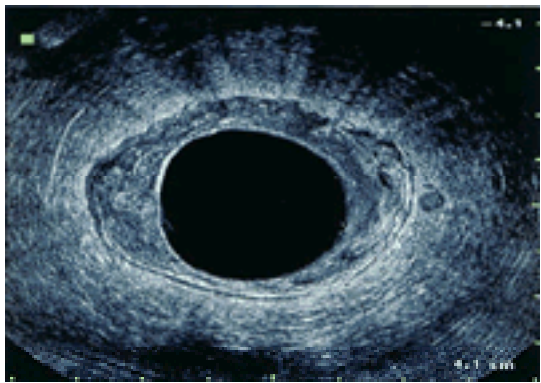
A transmural (T3N1) rectal cancer on endorectal ultrasound (it is important to remember that there is no serosa in the lower two-thirds of the rectum).
